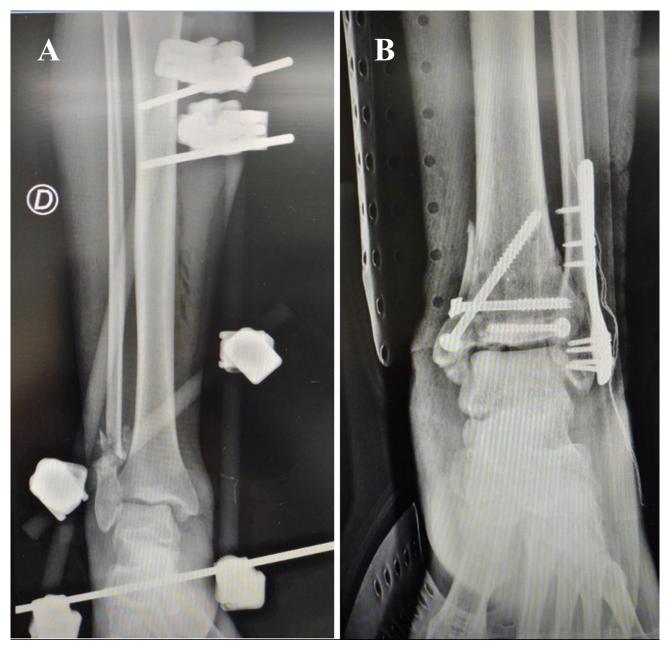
Post-operative X-rays. (A) Right leg, post-placement of the external fixator for tibia fracture stabilization. (The letter "D" indicates the right side of the patient.) (B) Left leg, post-open reduction and internal fixation (ORIF) with screws and plates.
